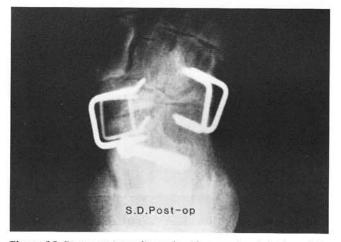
Postoperative radiograph with excessive abduction of the forefoot.
